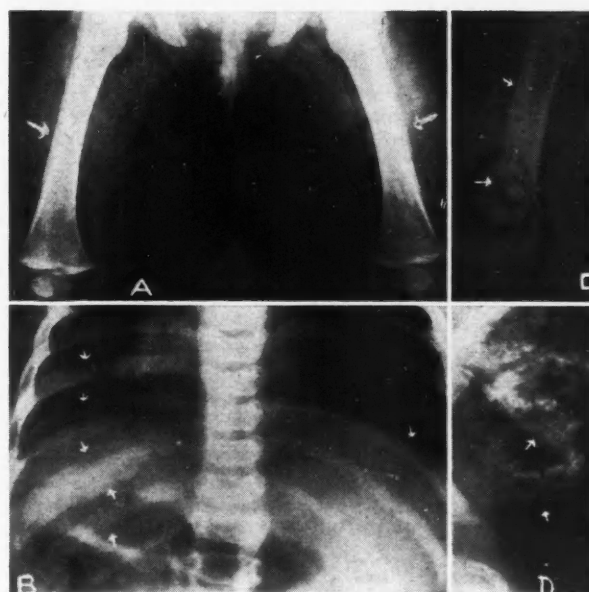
Roentgenograms, showing typical appearance of cortical hyperostoses of (A) femurs; (B) ribs, taken January 12, 1949; and (C) of the right femur; and (D) the mandible, seven weeks later. The left femur showed similar changes. The cortical changes in the mandible were present in the earlier x-rays, but are better demonstrated here.
